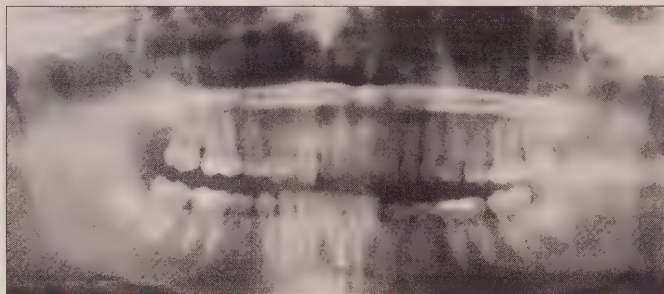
Panoramic radiograph of a 16-year-old girl two years after dislocating her left condyle (Case 2).
